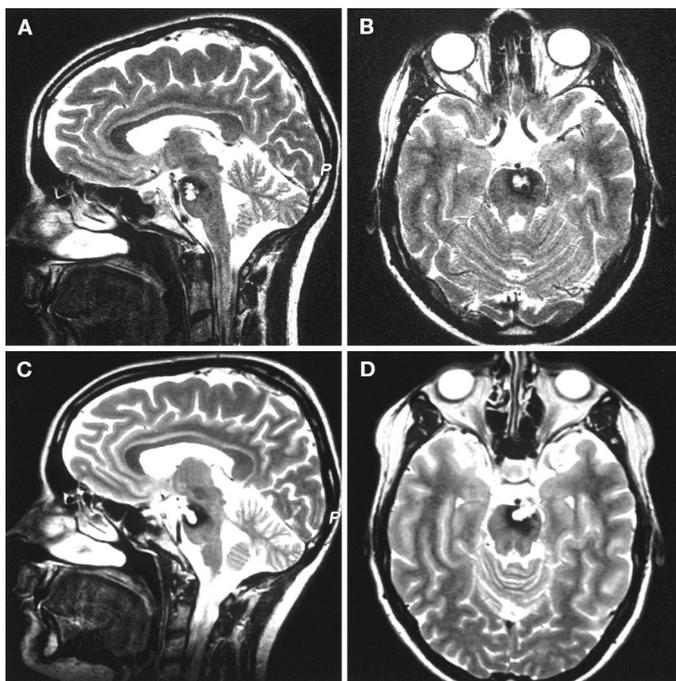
Preoperative and postoperative MRI scans of a 39-year-old woman with a ventrally situated pontomesencephalic brainstem cavernoma (A and B). The postoperative scans 3 months after surgery reveal complete removal of the cavernous malformation (C and D).
